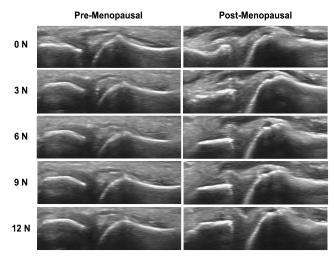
Representative ultrasound images of TMC joint under different traction forces for pre- and post-menopausal groups.
